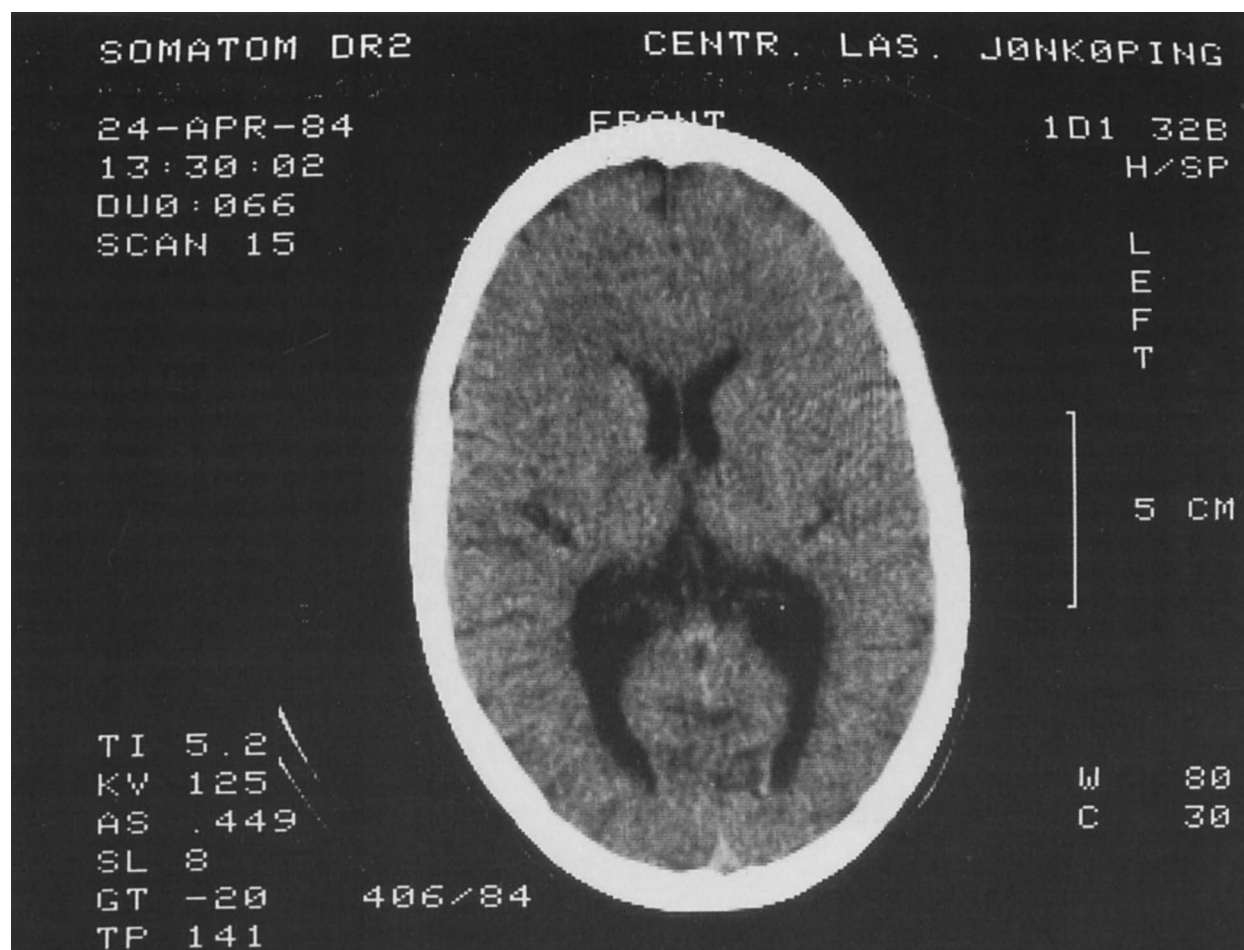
CT scan of the brain at 15 years of age showing demyelinating disease.
